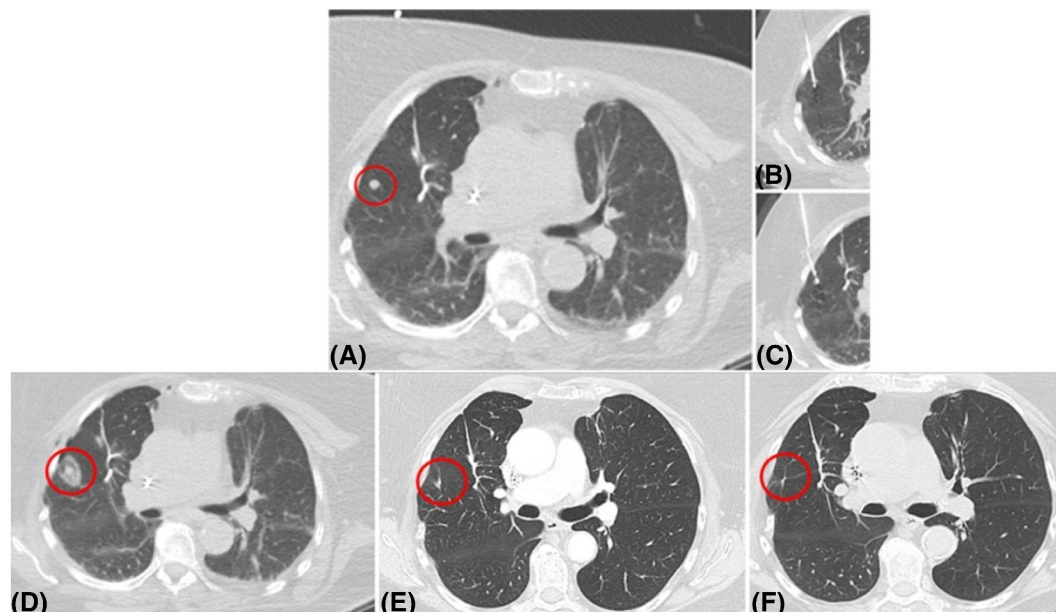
A woman aged 73 years with oligometastatic uterine sarcoma involving the lung. (A) Follow-up CT scans of a 7-mm lesion (red circle) in the right upper lung showed a progressive increase in size. (B,C) Cryoablation was performed using two probes surrounding the lesion. (D) An immediate postprocedure CT image demonstrated an adequate ablation zone encompassing the nodule with an adequate safety margin. (E,F) Follow-up CT scans at (E) 1 year and (F) 8 years after cryoablation revealed postablation changes with no signs of recurrent disease. CT indicates computed tomography.
